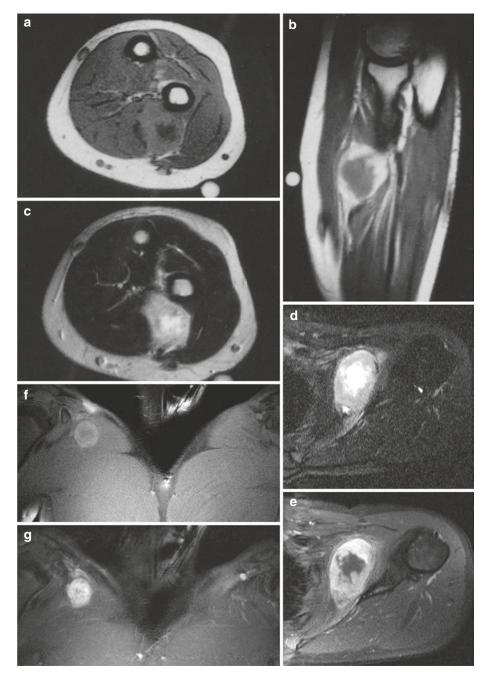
(a–g) Three cases of nodular fasciitis, intramuscular type: the first case (a–c) at the forearm, the second case (d, e) at the subscapularis muscle, and the third case (f, g) at the pectoralis muscle. (a) Axial spin-echo T1-weighted MR image. (b) Coronal spin-echo T1-weighted MR image after gadolinium contrast injection. (c) Axial spin-echo T2-weighted MR image. (d) Axial spin-echo T2-weighted MR image. (e) Axial spinecho T1-weighted MR image after gadolinium contrast injection, with fat suppression. (f) Coronal spin-echo T1-weighted MR image, with fat suppression. (g) Coronal spin-echo T1-weighted MR image after gadolinium contrast injection, with fat suppression. All three cases present with the so-called "inverted target" sign consisting of a peripheral zone of increased SI on T1-weighted MR images (a, f), decreased SI on T2-weighted MR images (c, d), and merely peripheral contrast enhancement (b, e, g)
